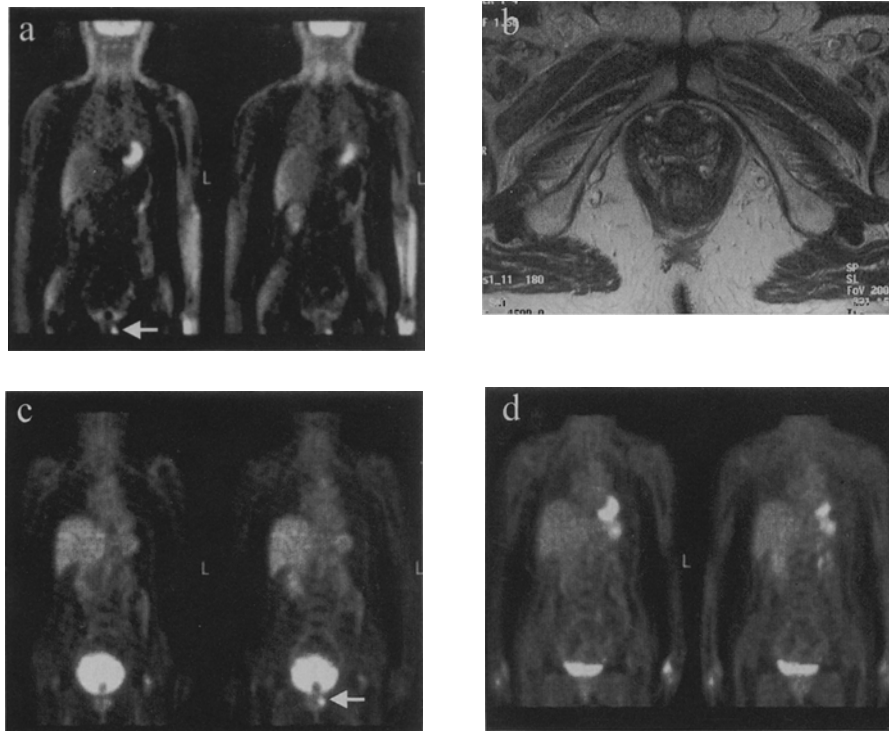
Endometrioid adenocarcinoma Grade 2, initial stage Ib (#6). The first FDG-PET, examined before the resection of local recurrence, clearly showed the recurrent focus in the vagina (a, *white arrow*), which was also detected by MRI. After resection and 2 courses of systemic chemotherapy, she developed another recurrent lesion in the vagina, which was unclear by MRI (b, T2WI) but was detected by FDG-PET (c, *white arrow*). After the operation, post-operative irradiation, and chemotherapy, the follow-up FDG-PET became negative (d) and she remained disease-free thereafter.
